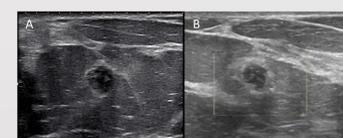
Left Breast Mass Ultrasound Correlate. Radial (A) and anti-radial (B) sonographic images at 6:00, 3cm from nipple demonstrate a round, circumscribed, parallel, hypoechoic 0.6 cm mass without posterior shadowing. Subsequent biopsy was consistent with fibroadenoma.
